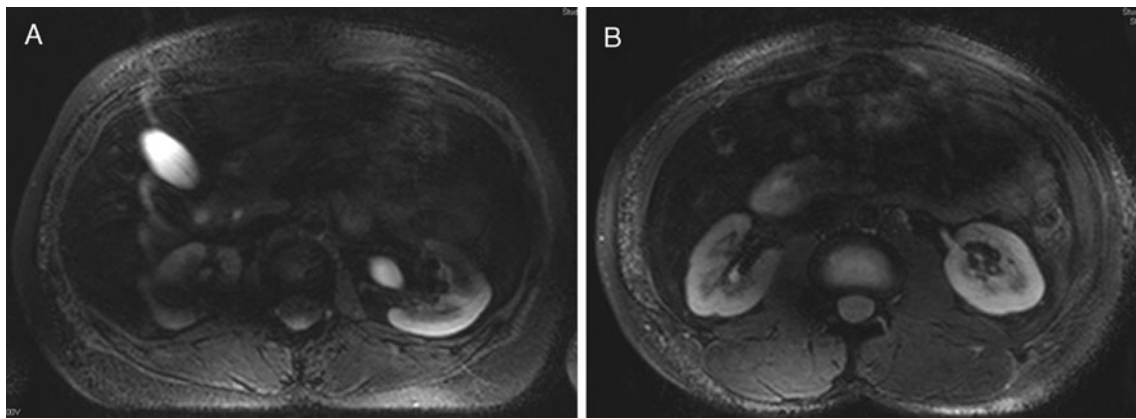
T2-weighted TSE imaging remained strongly impaired, as imaging in 3 subjects did not deliver any diagnostic value (a). In the remaining 5 subjects (b), TSE imaging provided mediocre image quality with a mean quality score of 1.38
